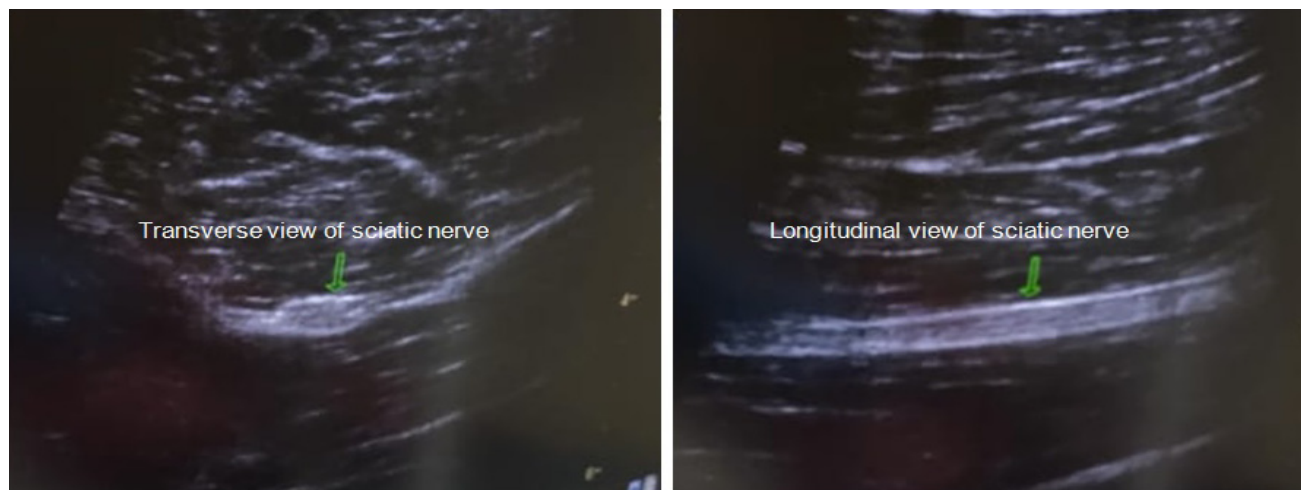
Ultrasonogram transverse and longitudinal view of sciatic nerve
